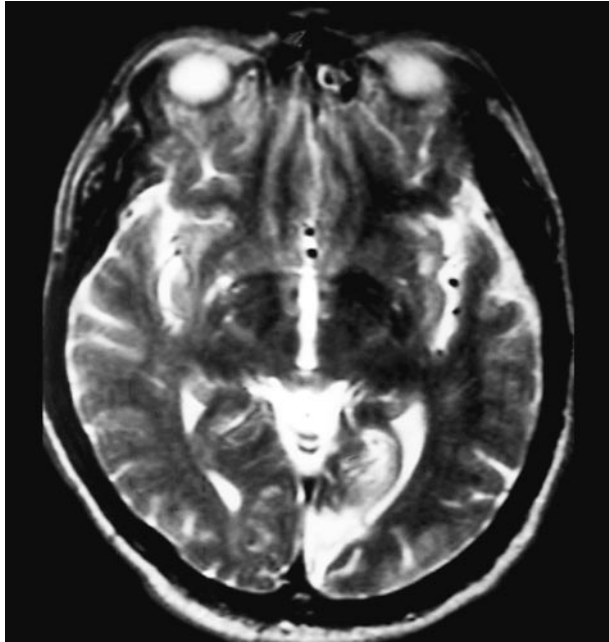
Axial T₂-weighted magnetic resonance imaging scan from patient 4 obtained 3 weeks after his stroke showing increased signal along the medial aspect of the left occipital lobe.
